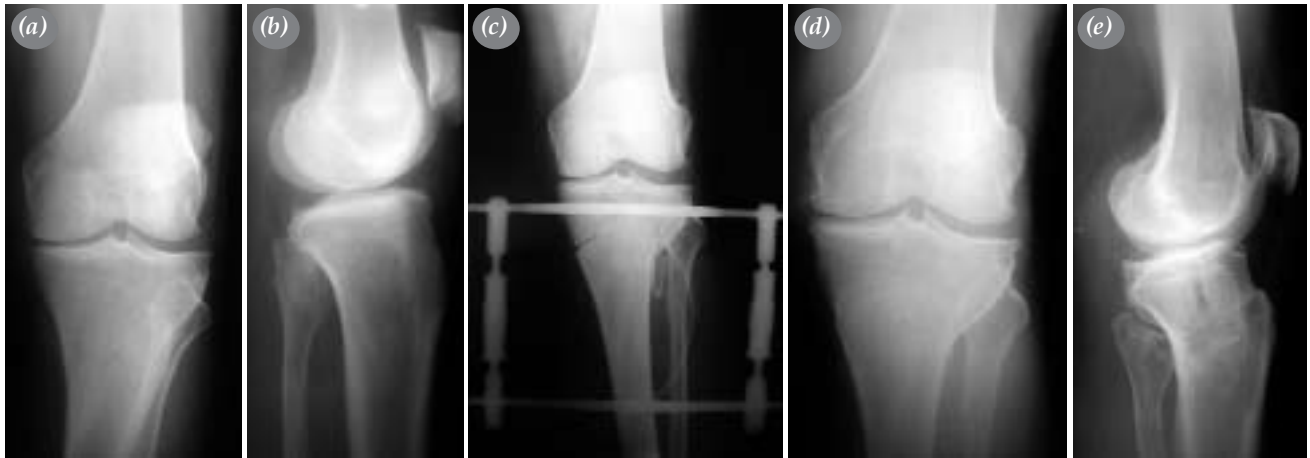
Radiographs of left knee with gonarthrosis in 60-year-old man. (a) Anteroposterior radiography. (b) Lateral radiography. (c) Early postoperative radiography. (d) Anteroposterior radiography 6 years after HTO. (e) Lateral radiography 6 years after HTO.
